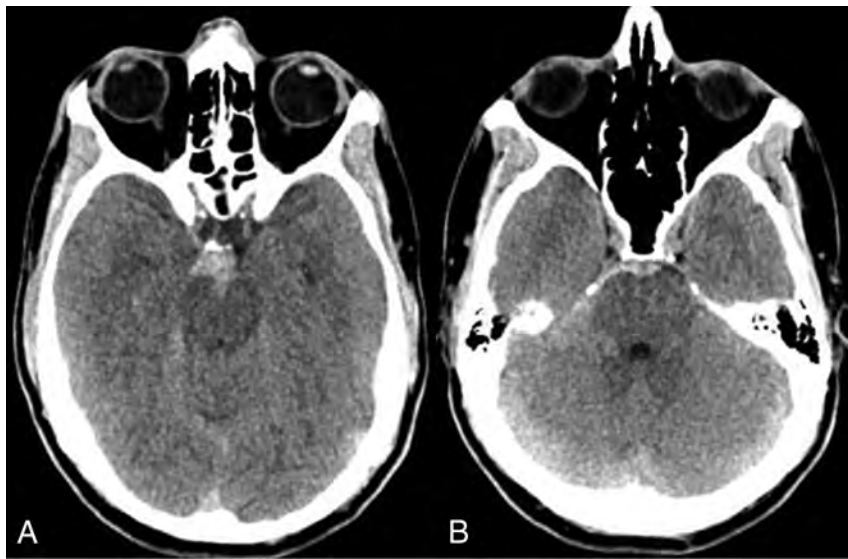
Pattern of nonaneurysmal perimesencephalic hemorrhage. Nonaneurysmal perimesencephalic hemorrhage in a 54-year-old man with a headache after sneezing. The CT demonstrates blood isolated to the perimesencephalic cistern with some extension into the right ambient cistern. No blood is seen in the bilateral Sylvian fissures, and there was no intraventricular hemorrhage.
